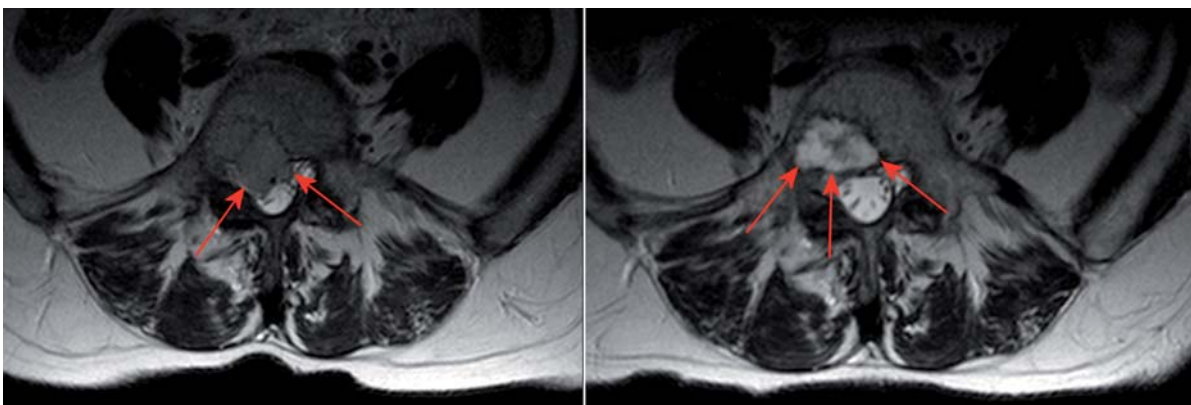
Axial T2-weighted MRI demonstrating the metastatic neuroendocrine tumour in the vertebral body of L5. Left panel shows the tumour appearance at baseline; right panel shows the appearance 9 months after radiosurgery. Note the tumour regression from the spinal canal, and the associated signal change.
